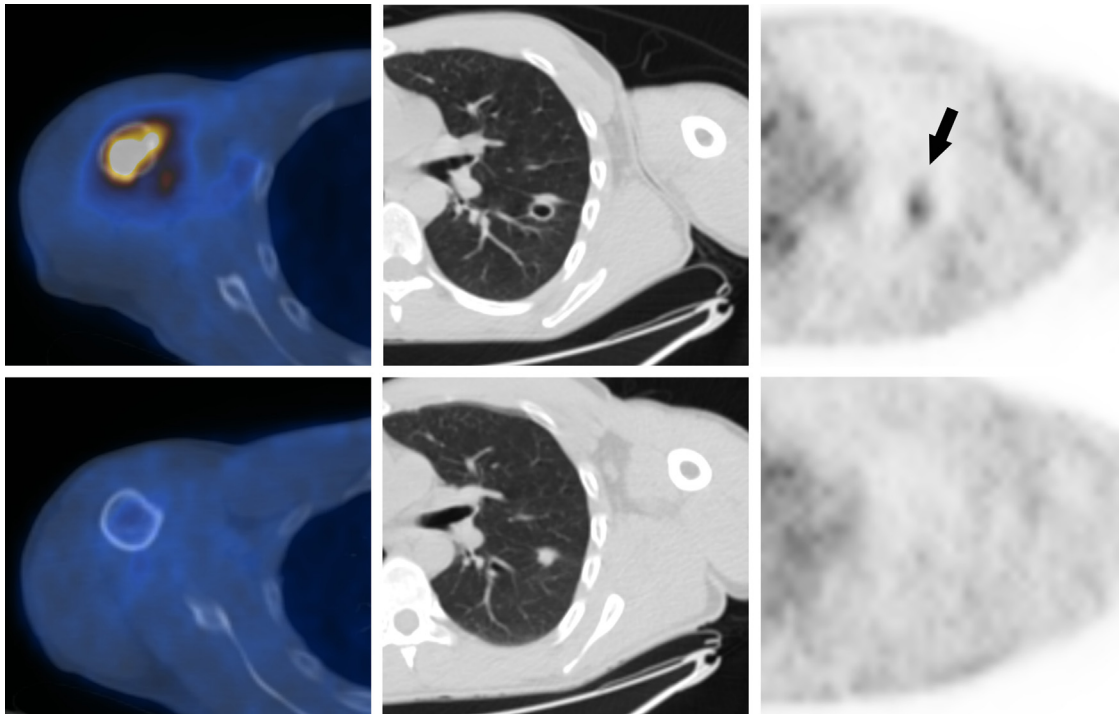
Top row, at diagnosis: left, osteolytic lesion of the right humerus with intense uptake of ^{18}F -FDG; middle and right, lung CT scan showing cavitary lesion in the left lower lobe; right, moderate ^{18}F -FDG uptake of the cavitary lesion. Bottom row, after 6 months of treatment: left, disappearance of ^{18}F -FDG uptake in the right humerus; middle, consolidation of the cavitary lesion; right, disappearance of ^{18}F -FDG uptake in the lung lesion.
